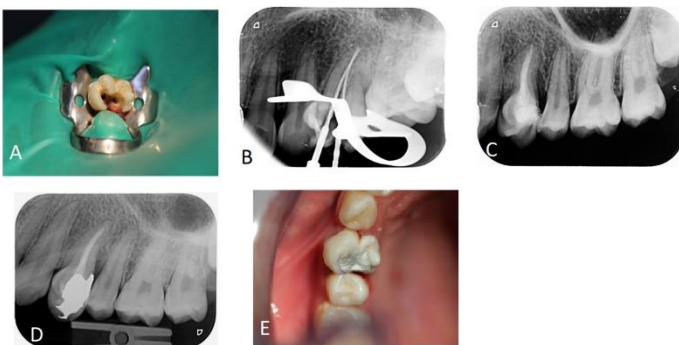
(A) two orifices at pulp chamber floor. (B) Working length radiography. (C) Post operation radiography. (D) 12 month follow up radiography. (E) 12 month follow up intra-oral photography.
